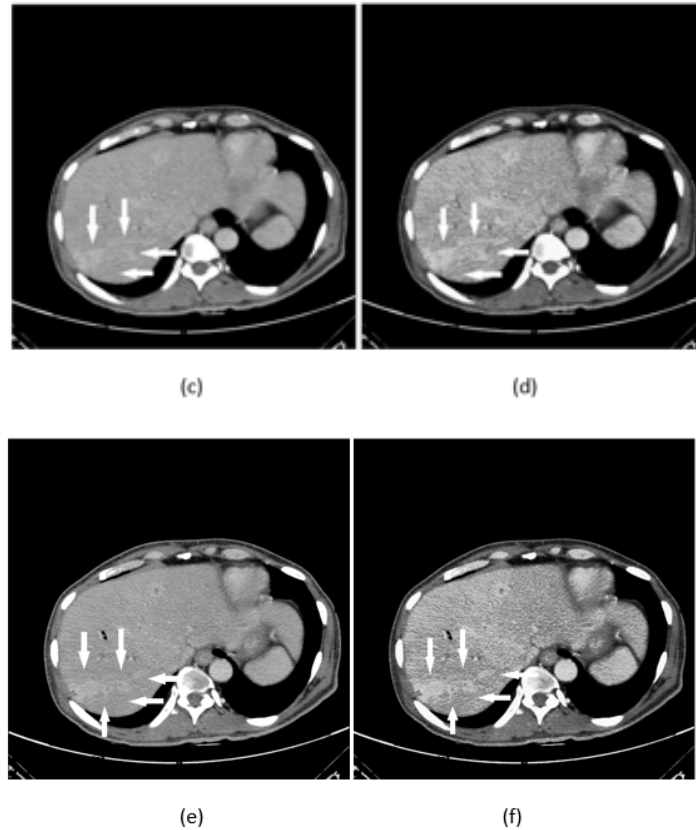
(a), (c), (e) are original CT images of liver and (b), (c), (d) are enhanced CT images of liver
